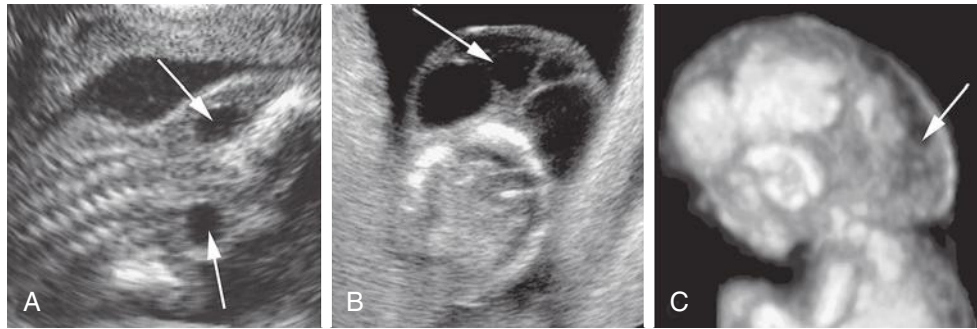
Nuchal cystic hygroma: A, Small hygroma in a second trimester fetus: two separate fluid accumulations (jugular sacs) are seen on each side of the neck (arrows). B, Large cystic hygroma (arrow) with septations in a fetus at 14 weeks' gestation. C, Three-dimensional ultrasound in surface mode in a fetus with a cystic hygroma (arrow).
